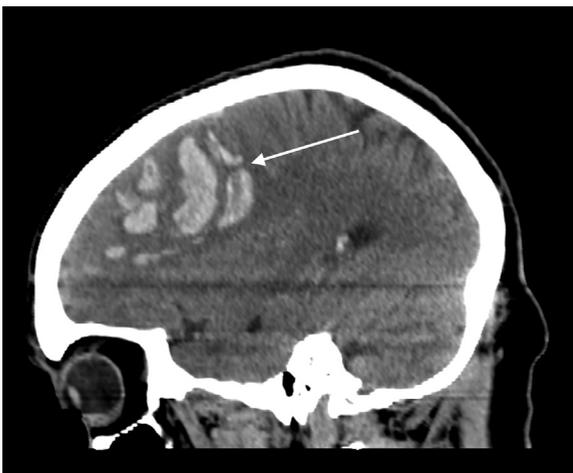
Computed tomography of the head with flame-shaped hemorrhage (arrow) in sagittal view.
